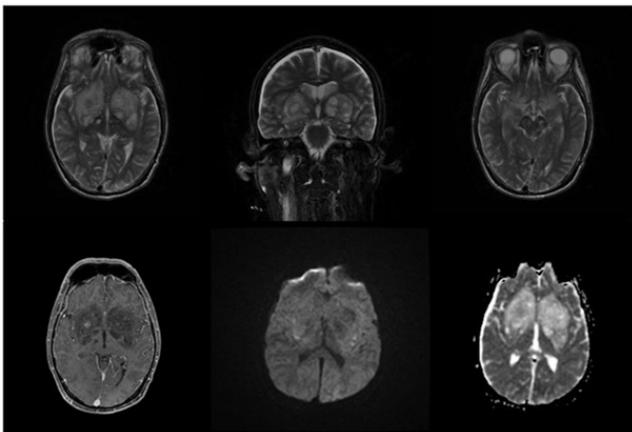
MRI T2, T1 contrast-enhanced, diffusion and apparent diffusion coefficient (ADC) map weighted images, depicting multiple dilated perivascular spaces in the basal ganglia in this immunocompromised patient with cryptococcal meningitis. Radiological signs compatible with gelatinous pseudocysts.
